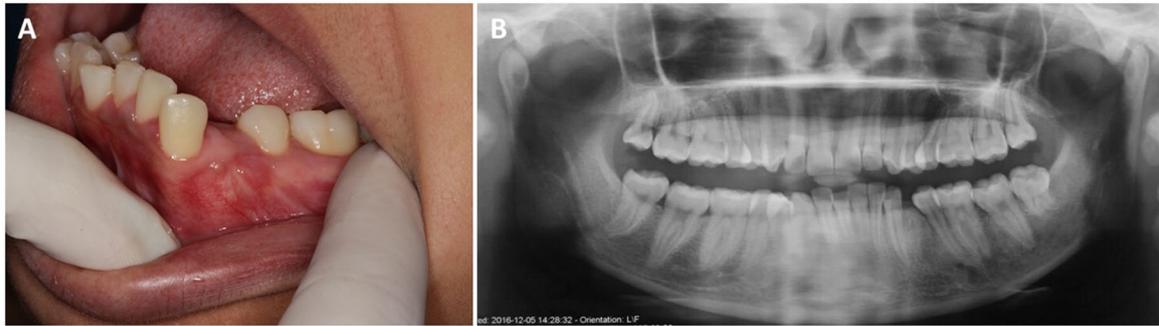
Follow-up after one year. A) Oral mucosa without signals of recurrence. B) Panoramic radiography showing complete bone healing.
